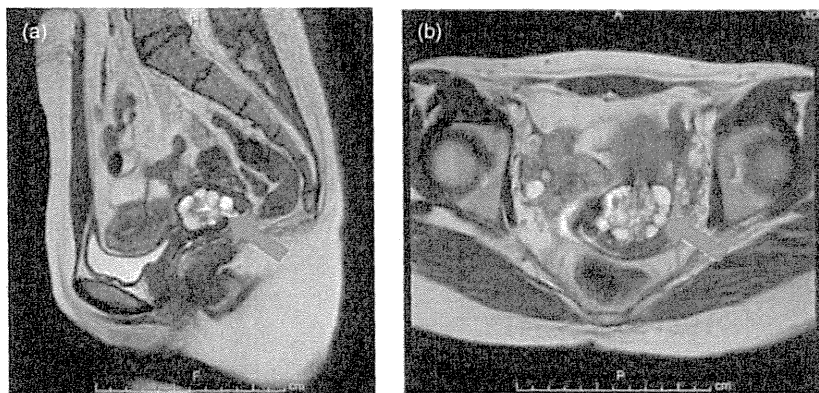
Magnetic resonance imaging on the first examination. T2-weighted image. (a) Sagittal and (b) transverse sections. Many cystic lesions showing a high intensity (arrow) were present in the uterine cervix.
